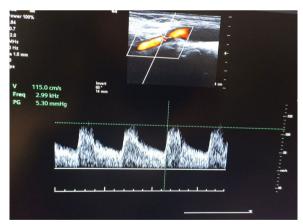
Duplex ultrasonography (USG) 12 months after surgery showing normal blood flow through the left internal carotid artery
